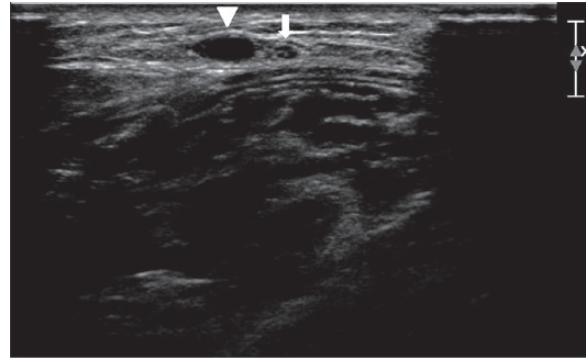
Ultrasonographic view of the sural nerve. The nerve appears a round/ovoid structure (arrow) and containing ‘black spots’ corresponding to nerve fibres, surrounded by an echogenic sheath (perineurium). The nerve is located in the saphenous compartment and next to the small saphenous vein (arrow head).
